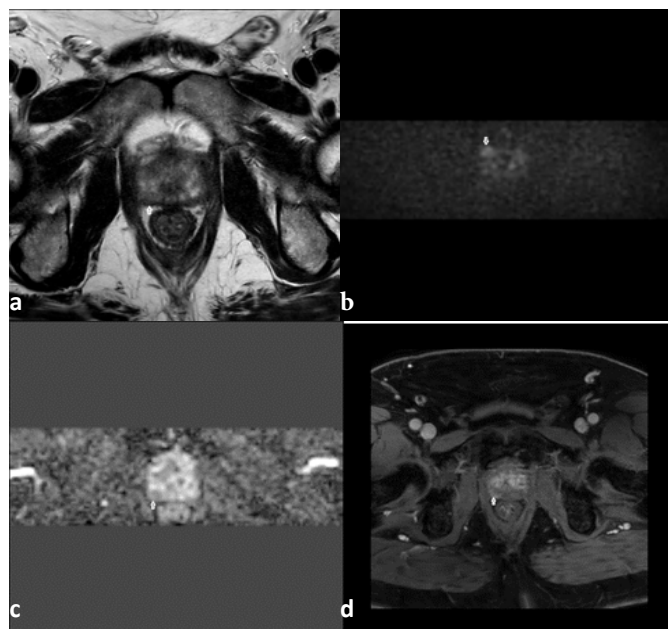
55-year-old patient with PSA 6.53 ng/ml, right peripheral zone hypointense area on T2 (a), minimal hyperintense focal area on DWI (b), hypointense focal area on ADC (c) and there is early arterial phase contrast enhancement in dynamic contrast images (d) PIRADS 4 lesion. Fusion biopsy result was compatible with Gleason score 3+3
